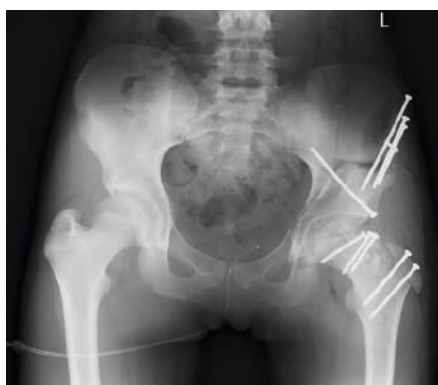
Post-operative radiographs 7 weeks after the FHRO. A reorientation of the acetabulum was additionally performed in this case to achieve optimal joint congruency
